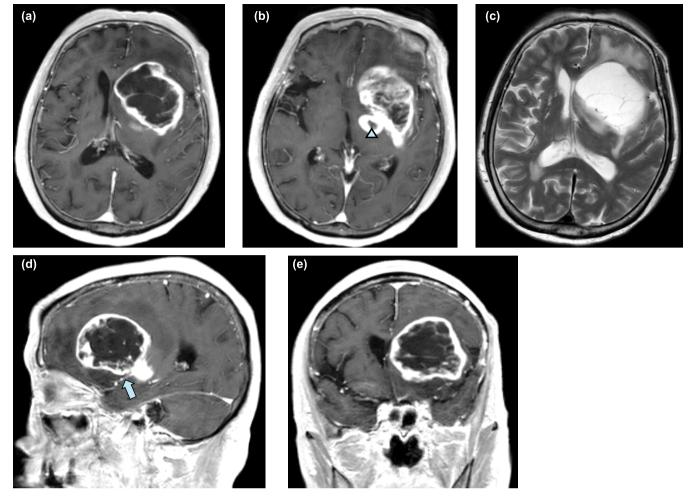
Preoperative MRI. Preoperative brain MRI, revealing a large cystic lesion mainly in the left insular cortex on T2WI (c). The lesion shows a ring-shaped enhancement on axial (a and b), sagittal (d), and coronal (e) post-enhanced T1WIs. It extends to the basal ganglia (arrowhead) and involves perforating arteries, such as the lenticulostriate artery (arrow). MRI, magnetic resonance imaging; WI, weighted image.
